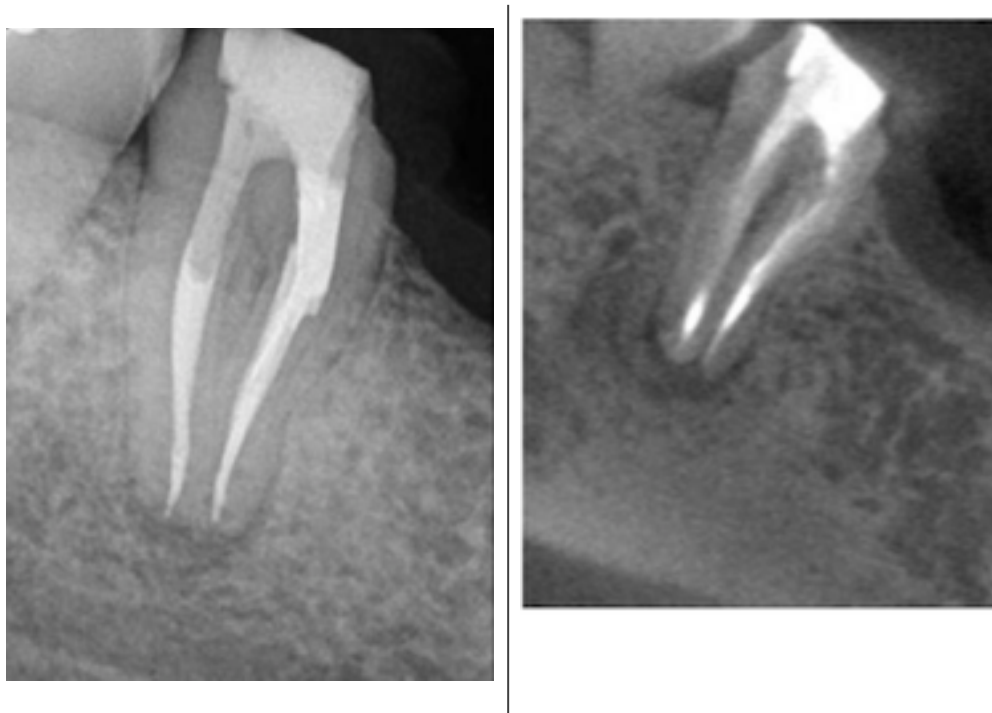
PA (left) and CBCT (right) axial scan of upper molar with missed MB2
